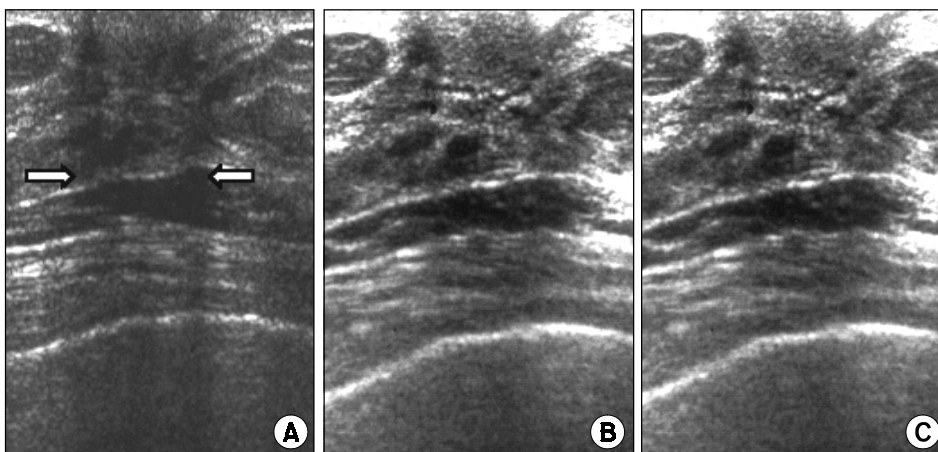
Conventional ultrasonography (A) shows extensive tissue shadowing in subareolar area. The density of shadowing (arrows) is more decreased on survey (B) and target (C) modes of RTCI. Thus, resolution of duct wall and lumen is improved on both modes of RTCI (B and C).
